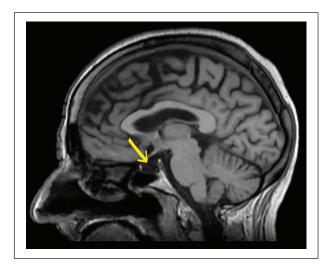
Sagittal gadolinium-enhanced TI-weighted MRI demonstrates an empty sella turcica (arrow).
